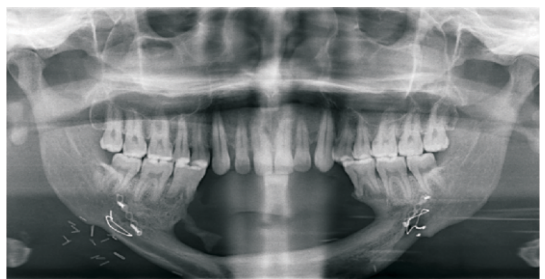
Panoramic radiograph revealing reconstruction with bone graft
